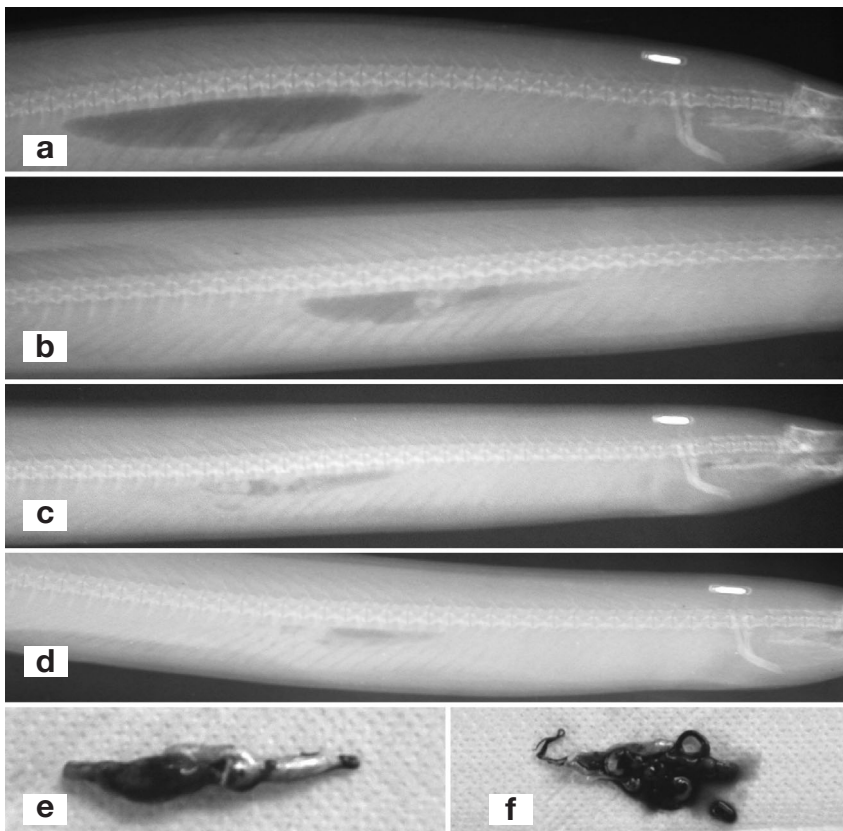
Anguillicola crassus* infecting *Anguilla anguilla*. Radiograph of eel in the 'mild swimbladder changes' category, with intact swimbladder at the first X-ray. (a–d) Status of the swimbladder gradually deteriorated during the study due to constriction of the lumen, thickening of the swimbladder wall and the growth of worms living in the lumen. (e) Swimbladder does not contain air; its wall is fibrotic, and the dilated pneumatic duct contains worms. (f) Lumen of the opened swimbladder, which has a thickened wall (2 mm), contains worm debris, and the pneumatic duct is completely filled by 3 worms. Reductions: (a,b) $\times 0.55$, (c–f) $\times 0.5$
